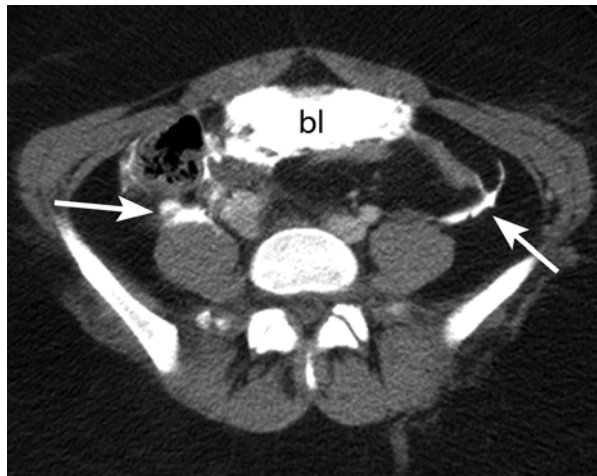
Bladder rupture. Computed tomography (CT) cystogram shows contrast in the bladder lumen (*bl*) and extravasation of bladder contrast (*arrows*) into the extraperitoneal spaces
